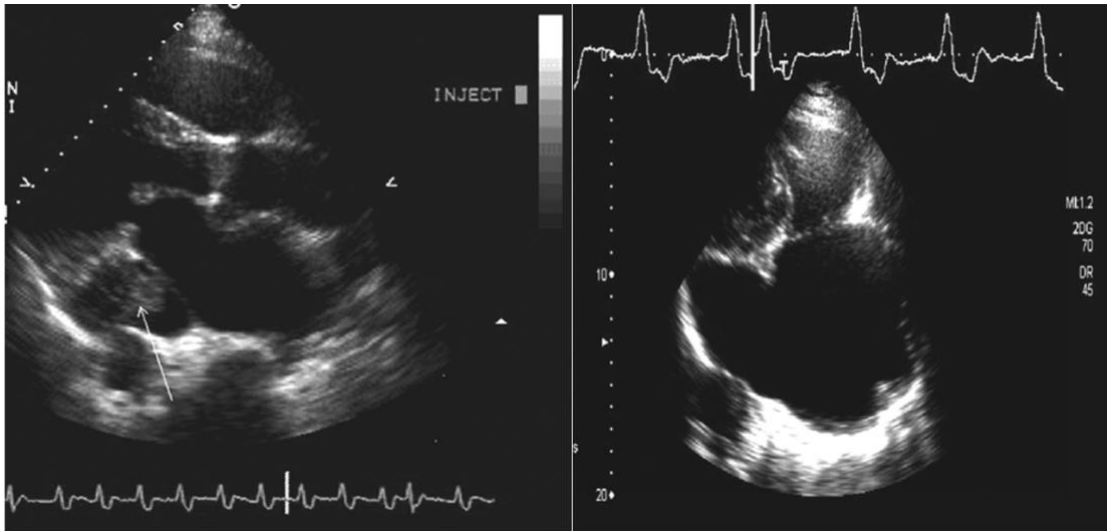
Cardiac Sonography with Bubble Study (36)
